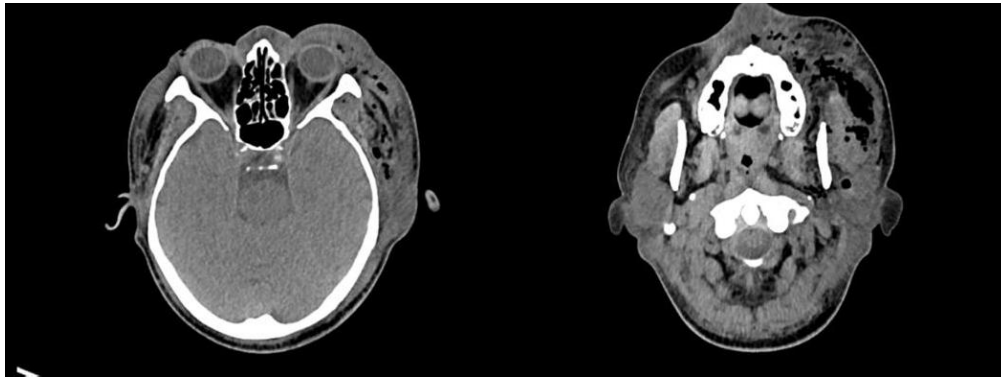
CT scan of the patient's head and neck.
